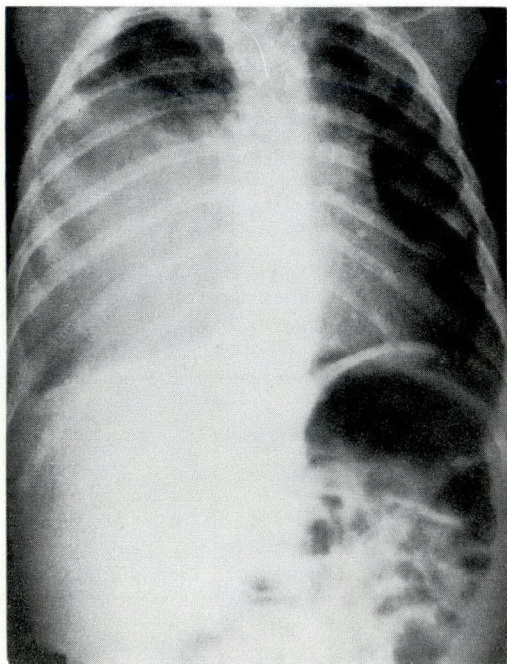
Case 2. Chest radiograph.
